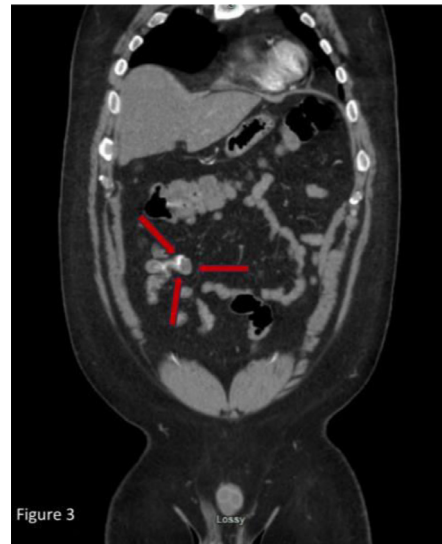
Representative coronal image of the abdominopelvic CT in the portal venous phase demonstrating thickening of the mucosa of the MD.
